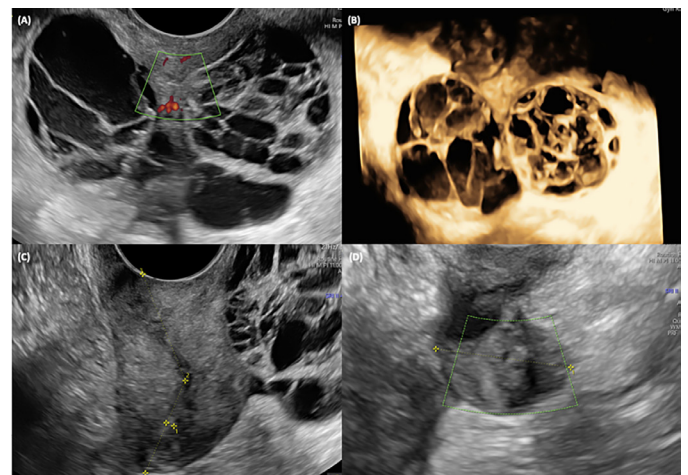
Ultrasonographic pelvic assessment (case 2). A solid multilocular cyst with a vascularized central solid part is observed on power Doppler (A). 3D appearance of the mass (B). The cyst was located posterior to the uterine body and cervix as clearly visible in the longitudinal scan of the uterus (C). The Pouch of Douglas was obliterated. Picture D shows the ultrasound appearance of the mass in May 2024, with the cyst no longer visible, appearing as ovarian parenchyma.
